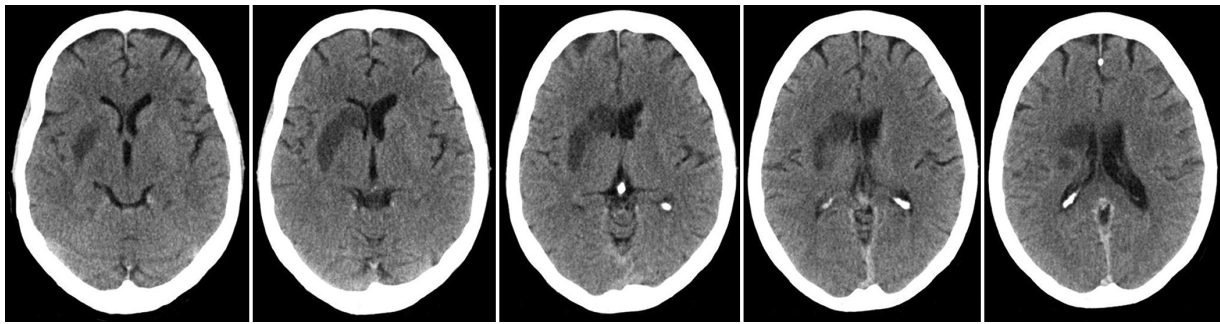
Plain computed tomography of the skull. A hypodense image can be seen that occupies the head of the caudate nucleus and the right basal gray nuclei, without mass effect on the midline structures, in relation to ischemic lesion at this level of probable embolic etiology based on the patient's history.
